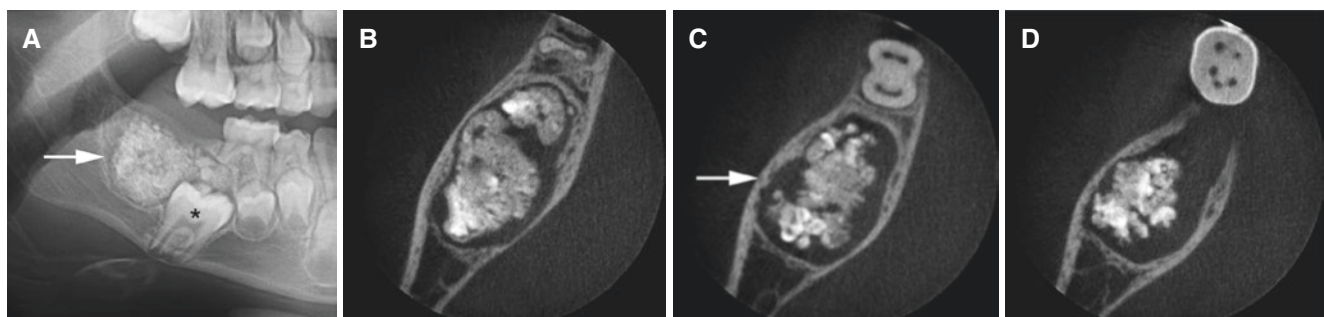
Odontoma (complex), mandible; 8-year-old male with unerupted first molar. (A) Panoramic view shows mass of multiple mineralized elements surrounded by radiolucent zone (*arrow*) and impacted first molar (*asterisk*). (B, C, D) Axial CBCT images confirm multiple
